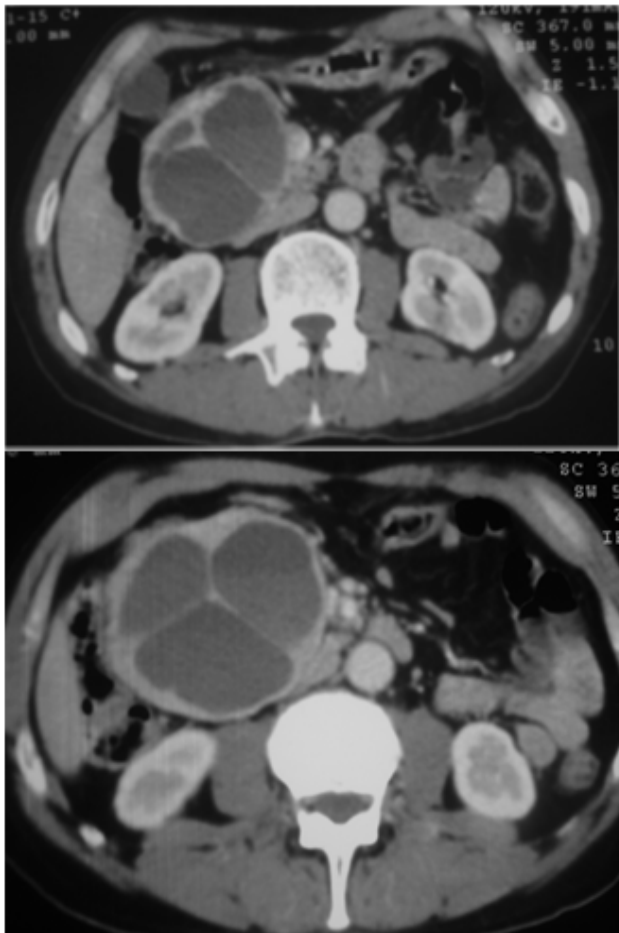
Contrast enhanced abdominal CT scan showing a solid cystic lesion of the pancreatic head.
